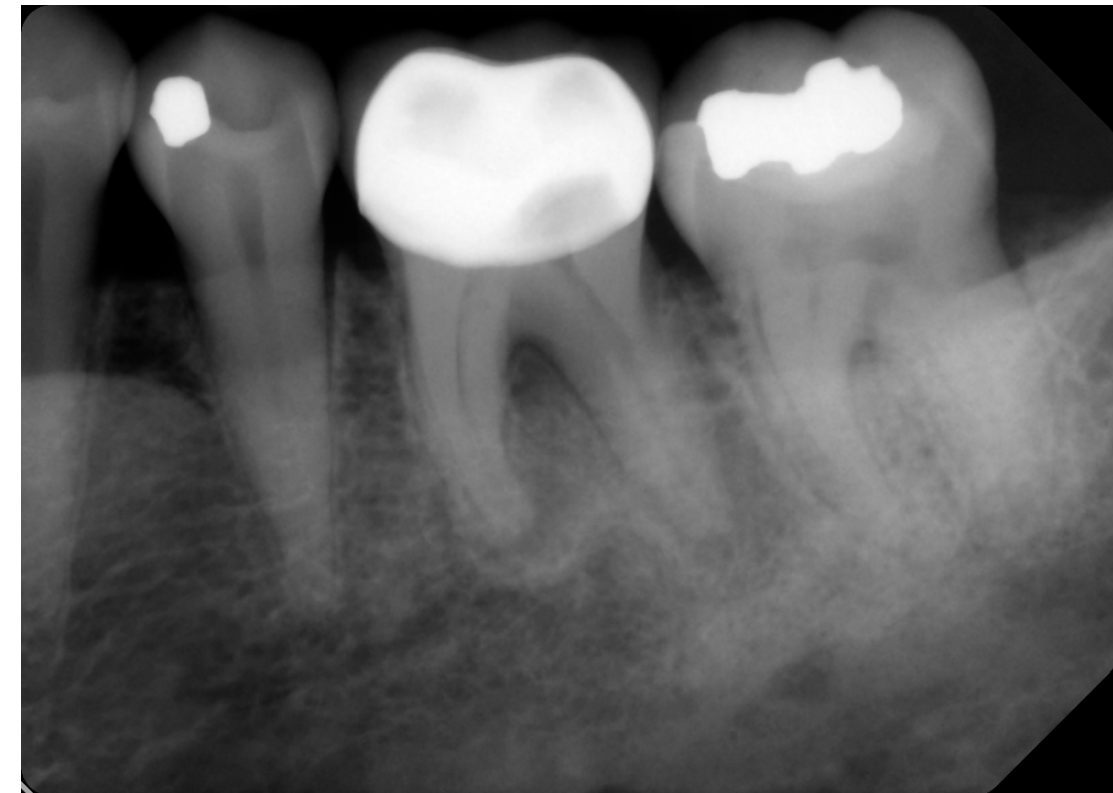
Classification of endodontic-periodontic lesions. A, Primary pulp infection can lead to chronic periradicular periodontitis by which a periapical radiolucency (PARL) can develop and migrate cervically. Mandibular molars can also have accessory canals in lateral orientation or in the furcation area. These accessory canals can allow migration of the primary pulp infection and cause secondary breakdown of the periodontium at their respected loci. B, Primary periodontal infection can lead to extensive breakdown of alveolar crest bone that migrates from the cervical area to the apex. In these lesions, one would find generalized bone loss around a single tooth or often might involve multiple adjacent teeth. Because of the pulpal-periodontal continuum through main root canal foramina or through accessory canals, extensive periodontal infection can cause irritation in the pulp tissues. C, Both primary pulp and primary periodontal infection can occur simultaneously in an “independent” endodontic-periodontic lesion, exhibiting the characteristics of both. D, Primary pulp and primary periodontal infections can occur extensively in this “combined” endodontic-periodontic lesion.
